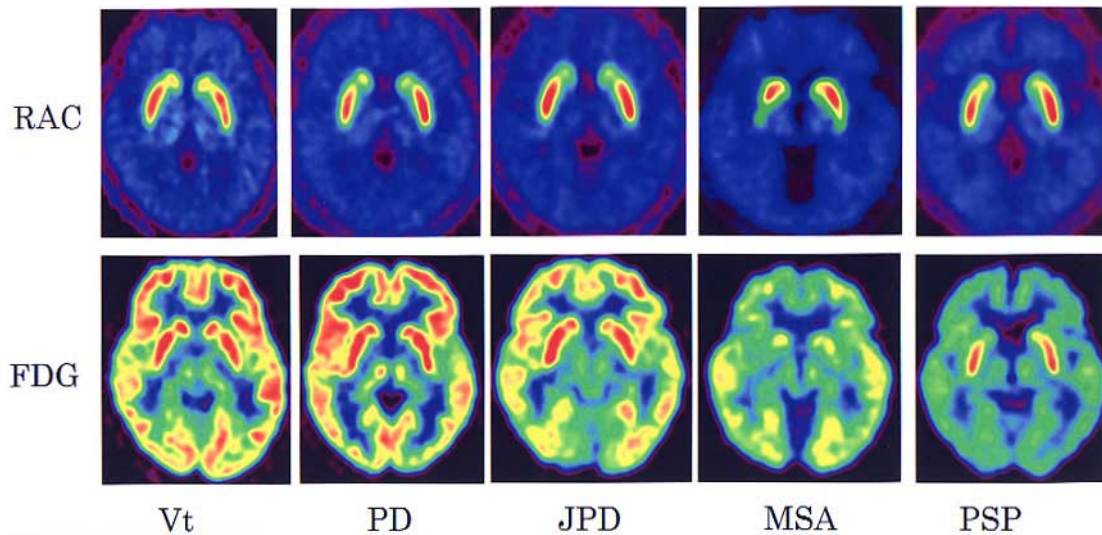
PET images of RAC (*top row*) and FDG (*bottom row*) through the putaminal level in normal volunteer, PD, JPD, MSA and PSP patients. The RAC images show a pattern similar to that observed in the CMRGlU images.
